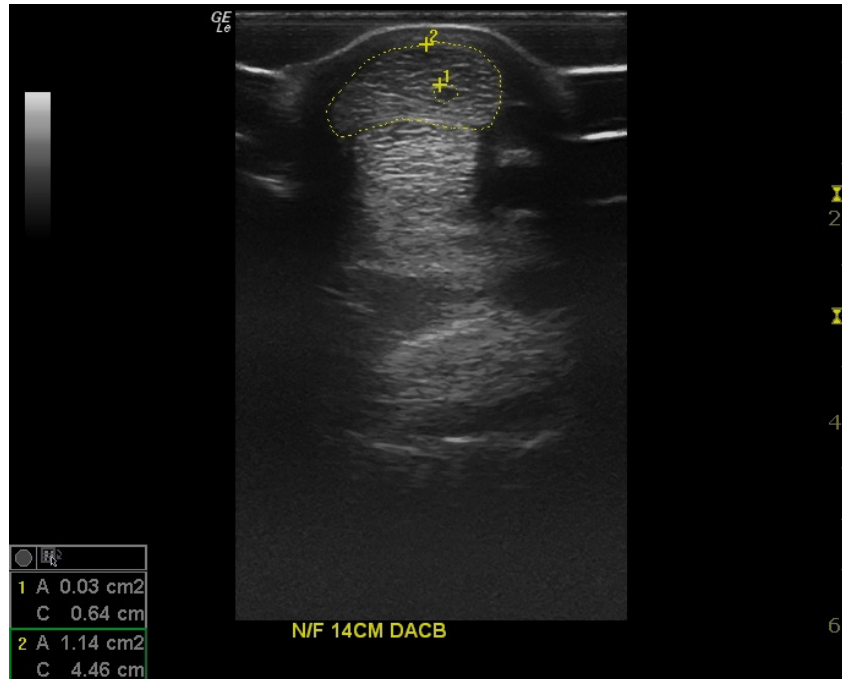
Ultrasound image showing microdamage (#1) in a superficial digital flexor tendon (#2). The small black hole was only apparent at one level of the tendon (14cm below the knee) and only represents 2% of the fibres within the tendon. The lesion was detected as an incidental finding on a routine scan.
